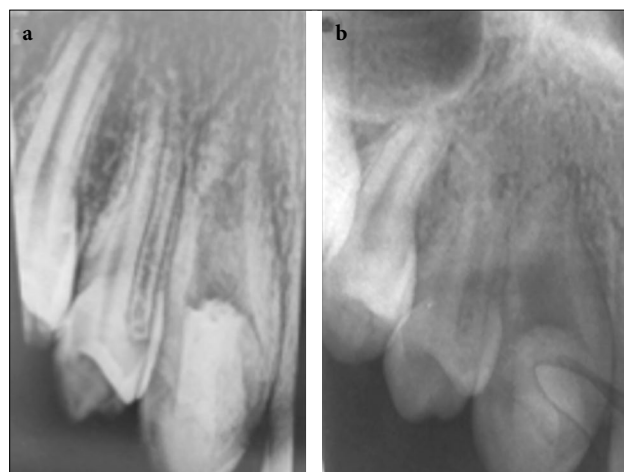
Platelet-rich fibrin membrane condensation in the root canal (a) radiographic control after Biodentine filling (b)
